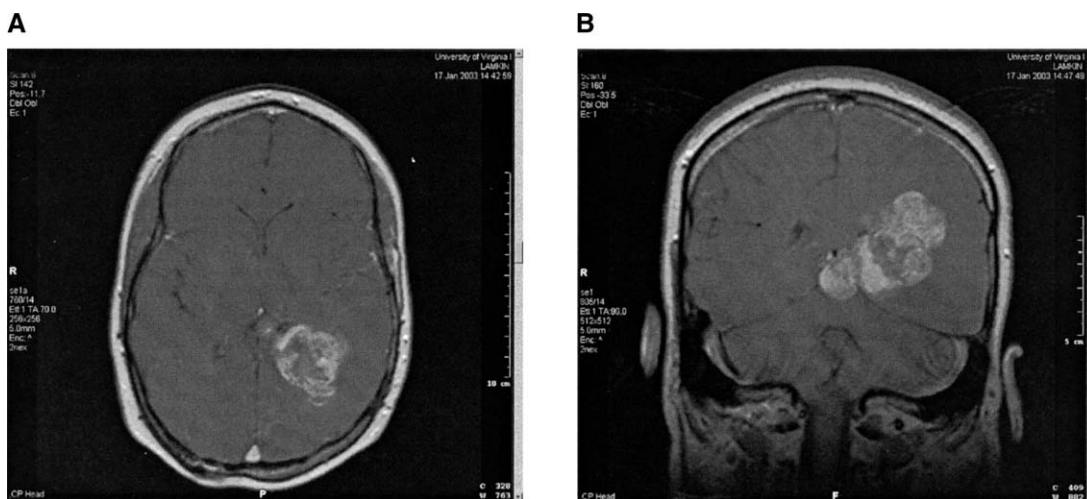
Subependymal giant cell astrocytoma. Axial (A) and coronal (B) MRI after intravenous gadolinium administration demonstrating an intensely enhancing mass expanding the atrium of the left lateral ventricle. This patient did not have stigmata of tuberous sclerosis.
